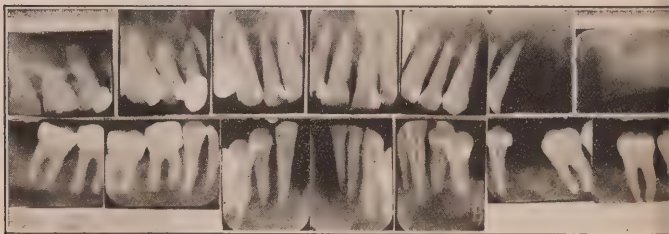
Full-mouth roentgenogram of the teeth in this case.
